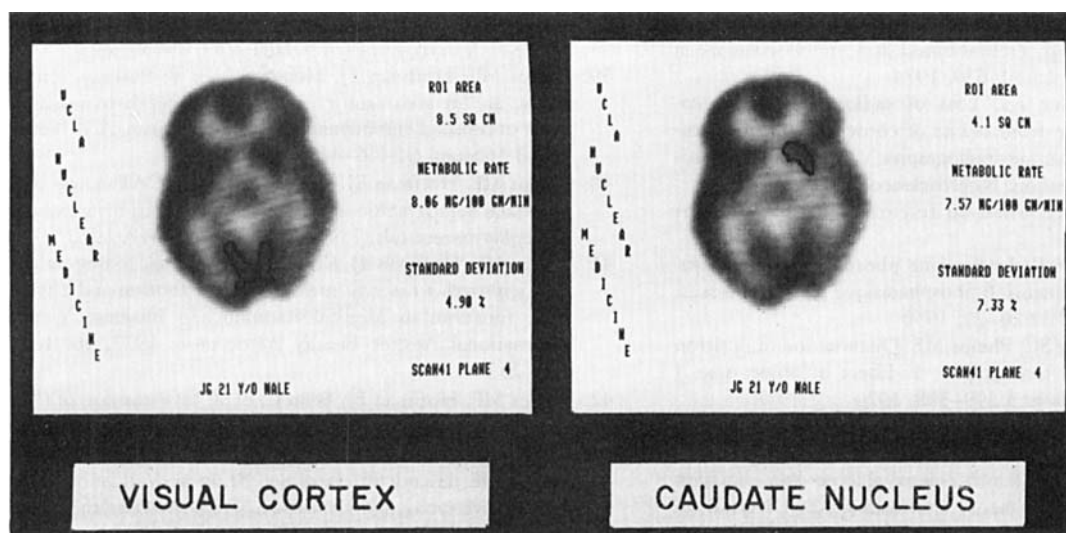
Region of interest (ROI) extraction of CMRGlc values. Eq. 23, measured values of  $k^*$ s, and LC are resident in the operating system software of the tomograph so that after plasma values of FDG and glucose are entered, the joy stick of the tomograph can be used to select ROIs for display of the ROI area, CMRGlc, and standard deviation of variation within ROI. As ROI is moved around the image, these parameters are updated in real time.
